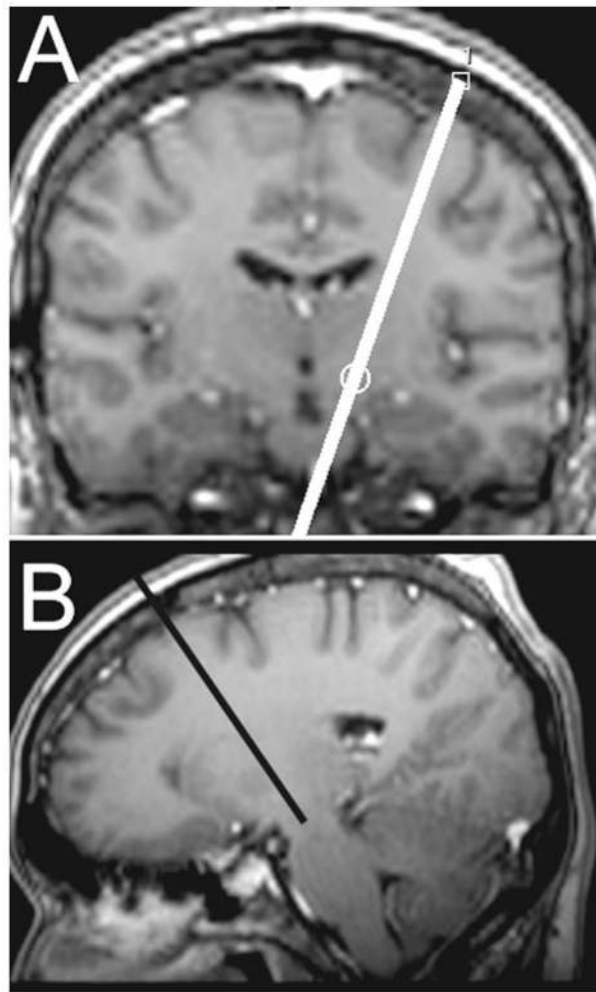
Magnetic resonance images showing the method of trajectory planning using reformatted oblique slices passing through the target, angled to exclude the lateral ventricle (MR protocol 1). A: First step. On a coronal plane passing through the target, an oblique sagittal plane is defined (*white line*) that avoids the lateral ventricle. B: Second step. The oblique sagittal plane selected in panel A is constructed on the MR console, and a safe trajectory (*black line*) to the target is planned.
